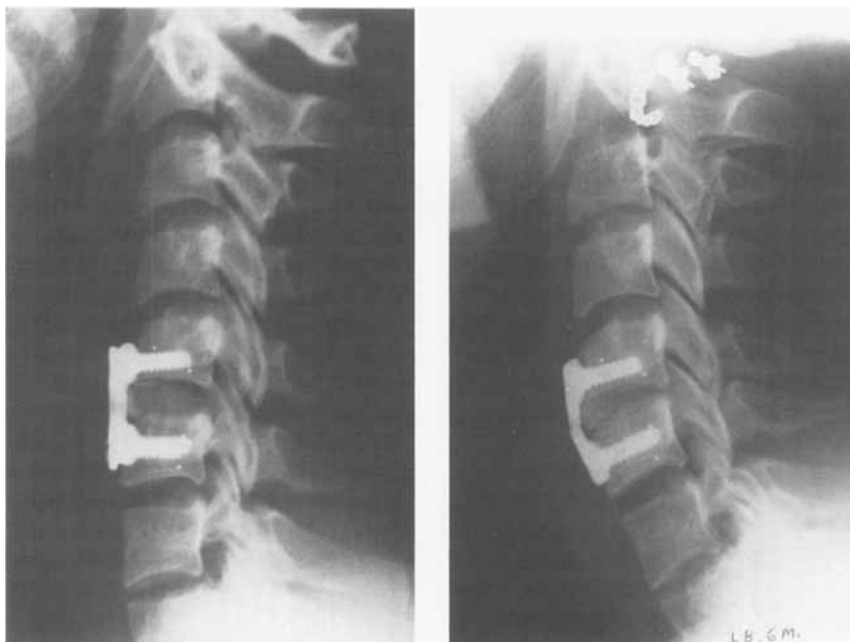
Postoperative radiograph of a patient who developed pseudoarthrosis (left). Same patient, 6 months postoperatively (right).
